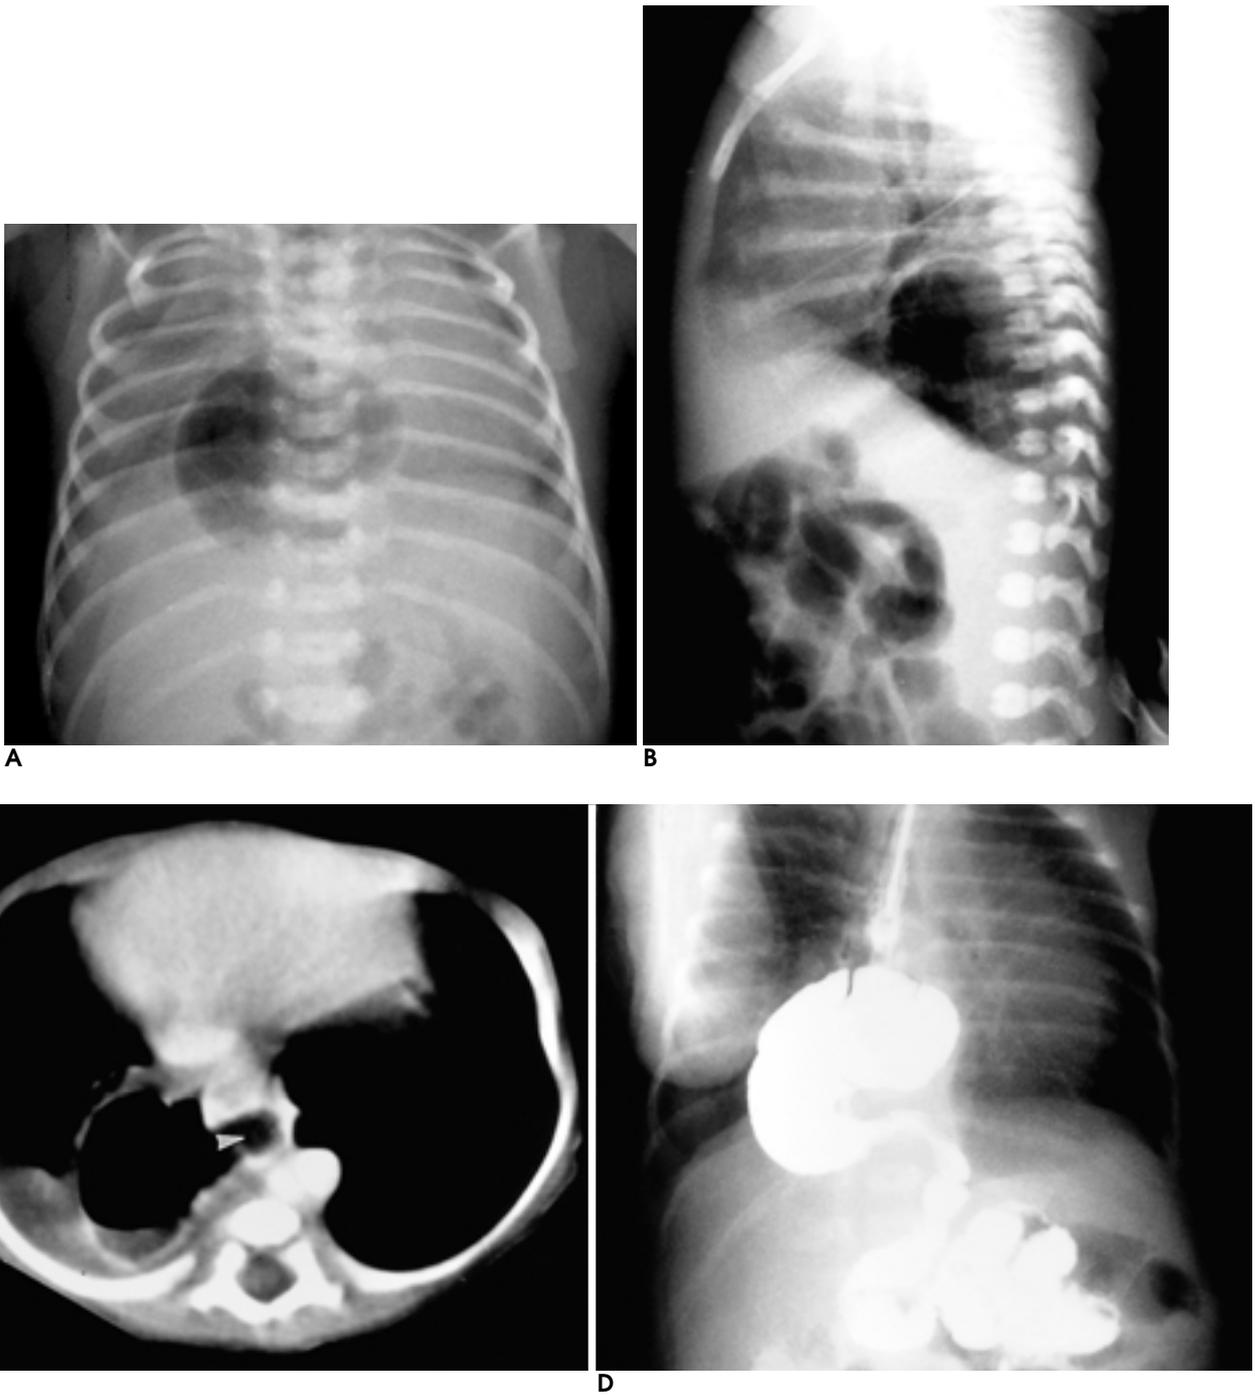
A, B. The chest radiograph shows air-filled stomach-like shadow in the right posterior hemithorax. C. CT shows a cystic mass in the right posterior mediastinum. This mass is connected to the esophagus(white arrowhead). D. Barium meal examination shows a partial right intrathoracic stomach with the greater curvature lying against the right chest wall and non-obstructive orogastric torsion. The esophago-gastric junction is above the diaphragm.
